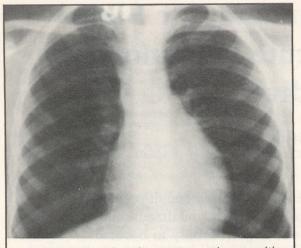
Admission chest x-ray study was without infiltrate (Case 1)
